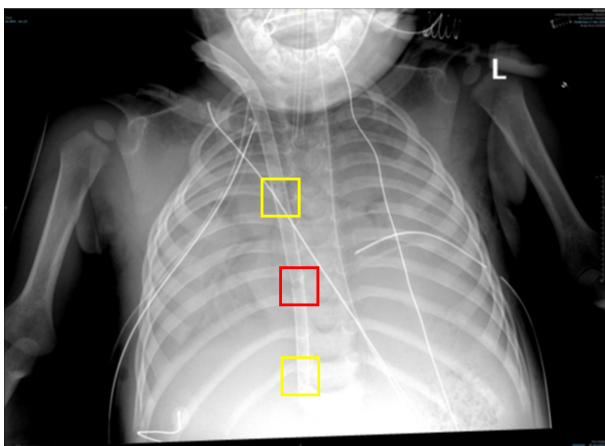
Postoperative chest radiograph showing the Avalon Elite bicaval dual lumen catheter positioned through the right internal jugular vein. The return port (red square) is positioned over the tricuspid valve while the two withdrawal ports are situated in the superior and inferior vena cavae (yellow squares).
